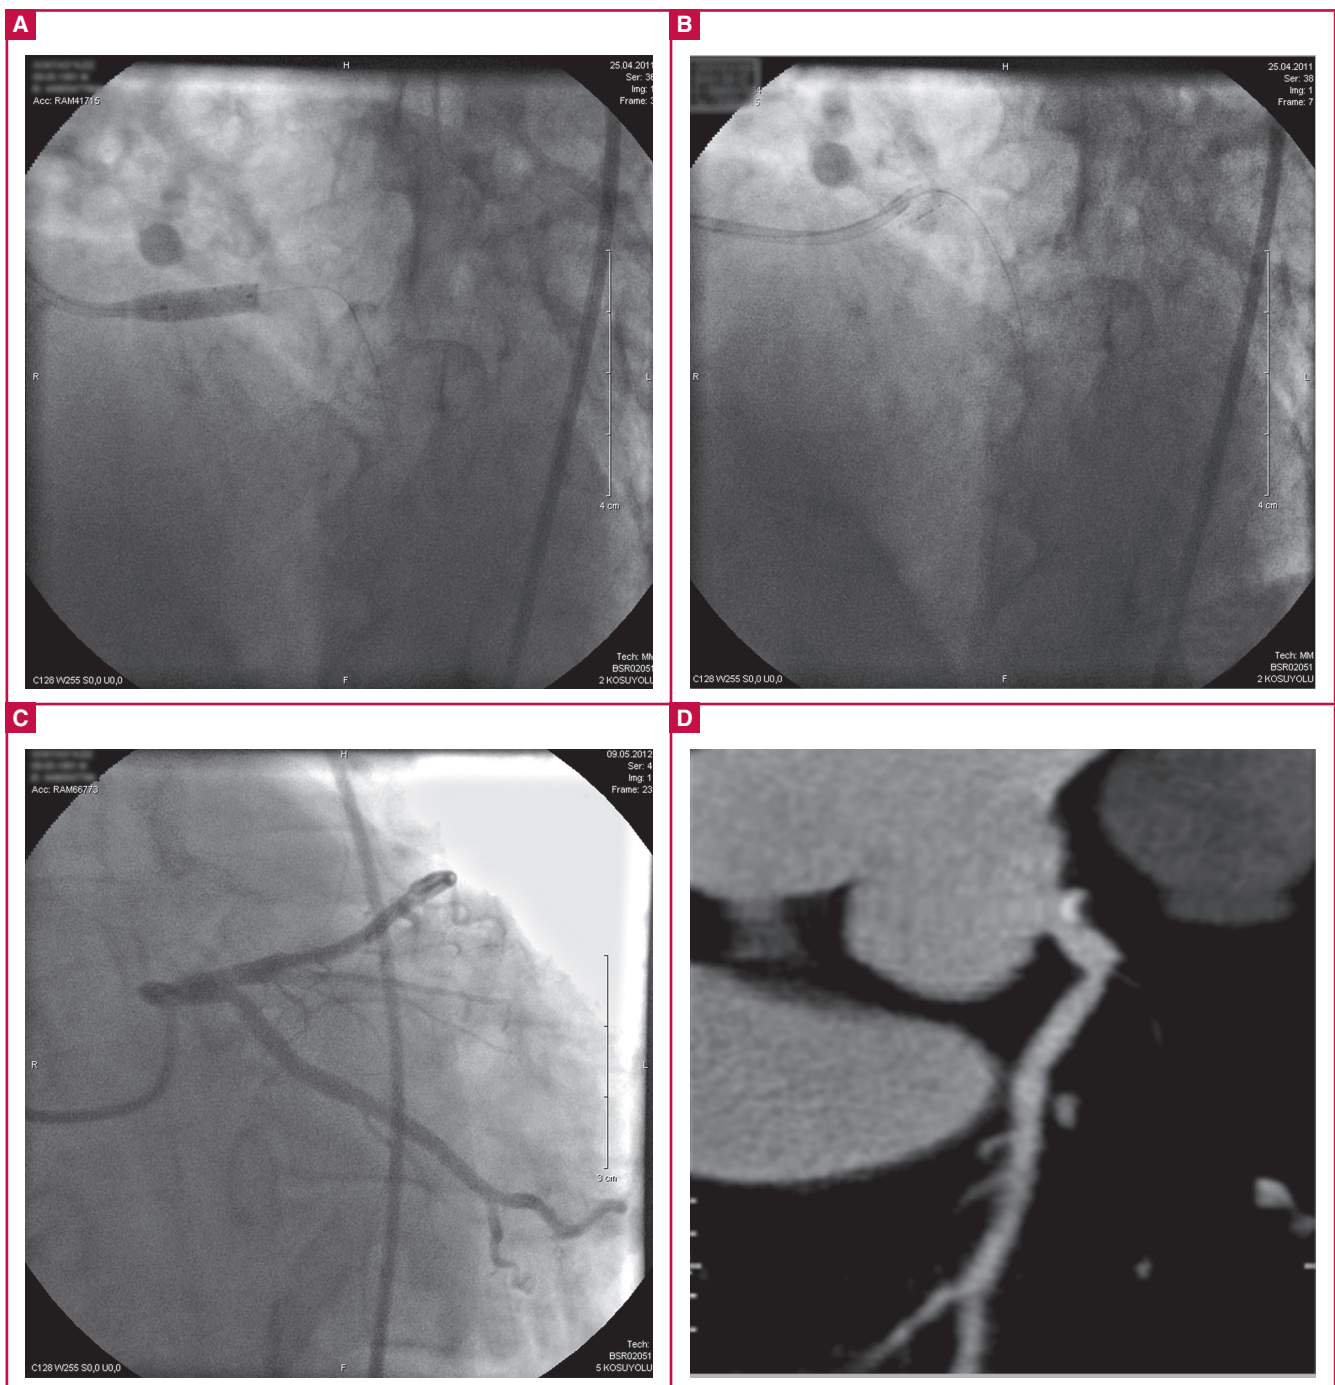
A, B: Coronary angiography showing the stent implanted in the LMCA during baseline coronary angiography. C: Coronary angiography showing absence of the stent in repeated coronary angiographs. D: Computed tomography coronary angiography showing the absence of the LMCA stent.
